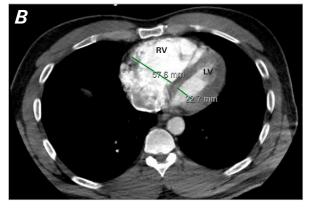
Computed tomography pulmonary angiogram shows (A) a saddle embolus (SE) involving the left pulmonary artery (LPA) and right pulmonary artery (RPA), with near occlusion of the left pulmonary artery noted. B) Computed tomogram (axial imaging) of the heart demonstrates marked dilatation of the right ventricle (RV), with an increased RV-to-left ventricle (LV) diameter ratio of 2.5.
